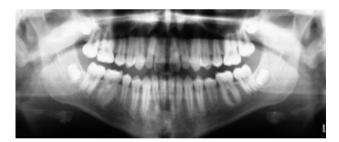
Case 2: Panoramic radiograph 27/07/99. Radiograph available from general dental practitioner records showing unrestored adult dentition with normal dental development (pre-molars have not completed development at this stage). No evidence of root resorption.
